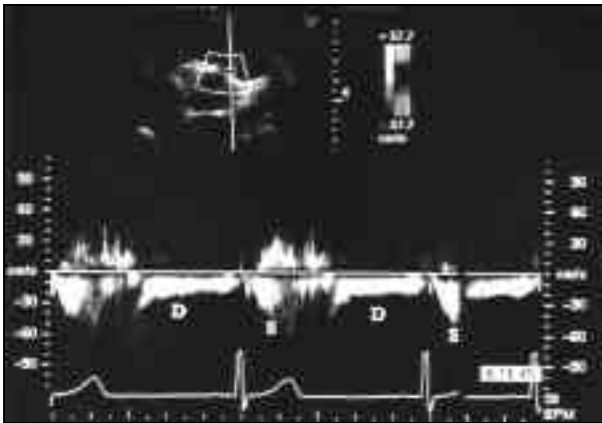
(A) A normal spectral Doppler flow pattern seen in the anomalous left main coronary artery. A pandiastolic (D) and a short systolic (S) flow are seen. This shows a non-obstructed flow pattern.
